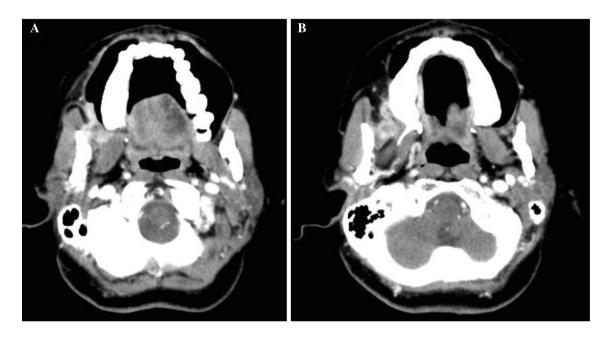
CT scan axial view showing involvement of pterygoids by the tumor in infratemporal fossa
